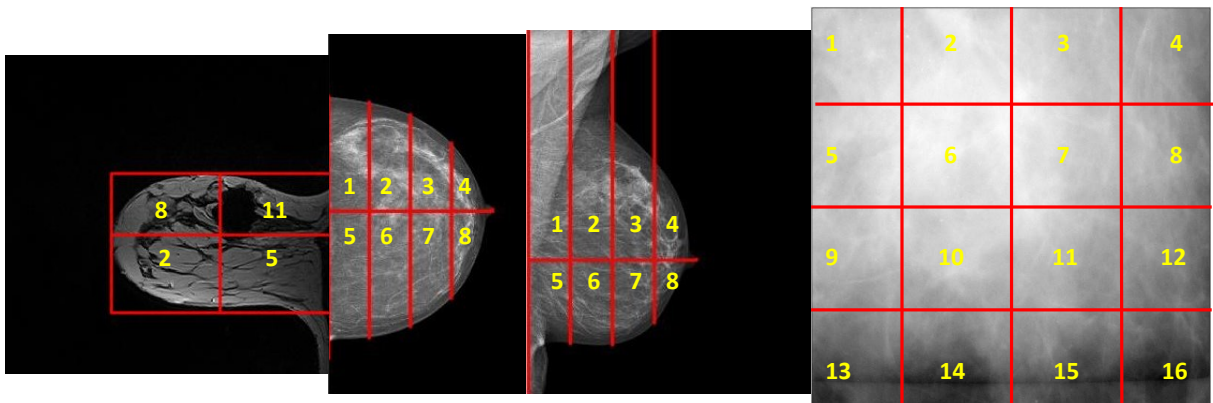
Definitions of regions in each modality: MRI: four regions are shown in this example which are R8, R11, R2, and R5 (left). Full X-ray mammogram: all regions available for the two views CC and MLO are shown in this example from R1 till R8 (middle). Spot mammogram: all regions available for spot mammogram are shown in this case from R1 till R16 (right).
